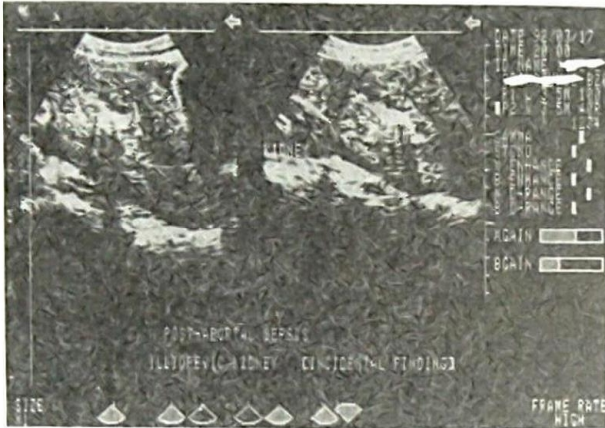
Longitudinal ultrasound scans showing a bulky, brightly echogenic uterus. There is a thick, intrauterine, echogenic structure with a thin halo of fluid, from retained products of conception, accompanied by thin, linear posterior acoustic shadows. Note the presence of a pelvic kidney (incidental finding) posterior to the uterine fundus and minimal clear fluid around the uterus.
